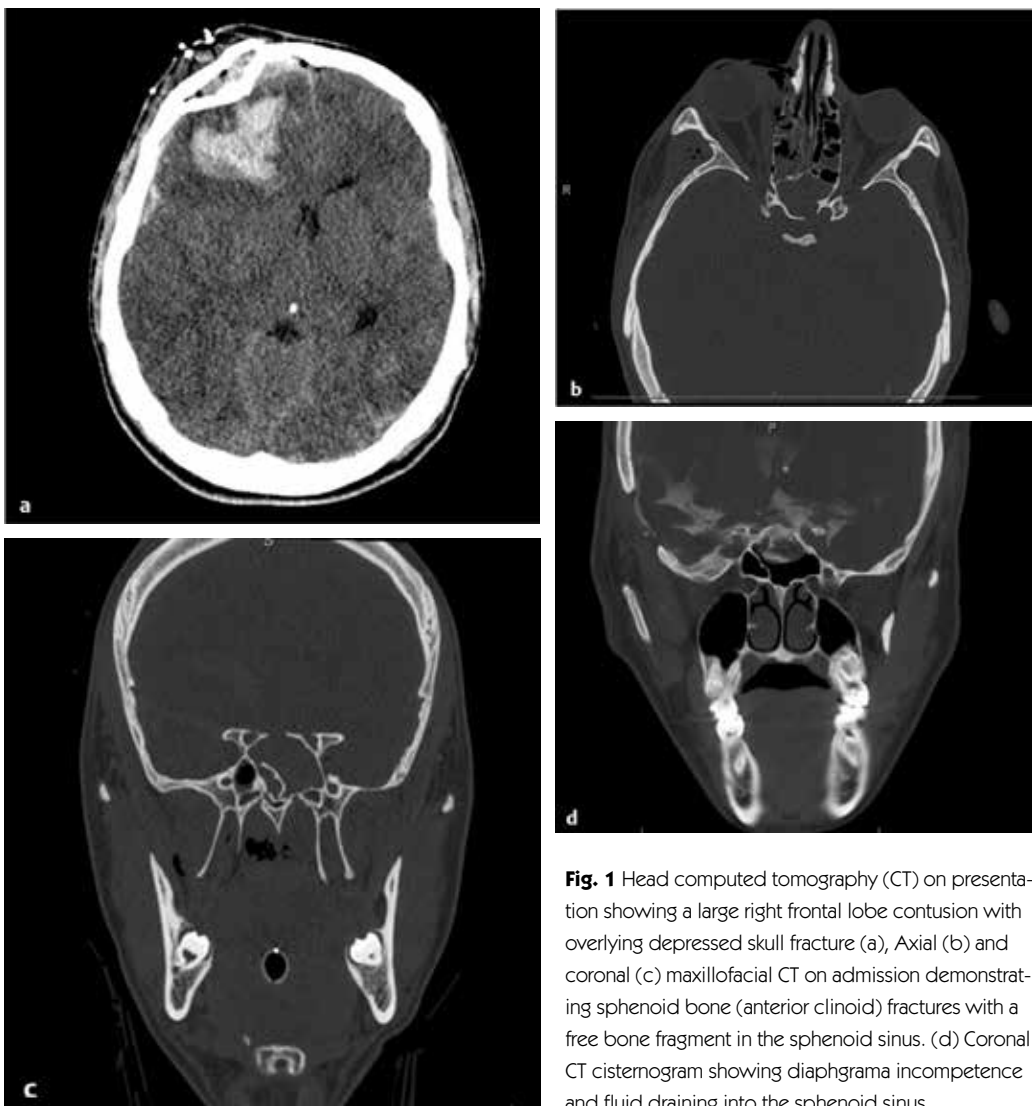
Head computed tomography (CT) on presentation showing a large right frontal lobe contusion with overlying depressed skull fracture (a), Axial (b) and coronal (c) maxillofacial CT on admission demonstrating sphenoid bone (anterior clinoid) fractures with a free bone fragment in the sphenoid sinus. (d) Coronal CT cisternogram showing diaphragma incompetence and fluid draining into the sphenoid sinus.
